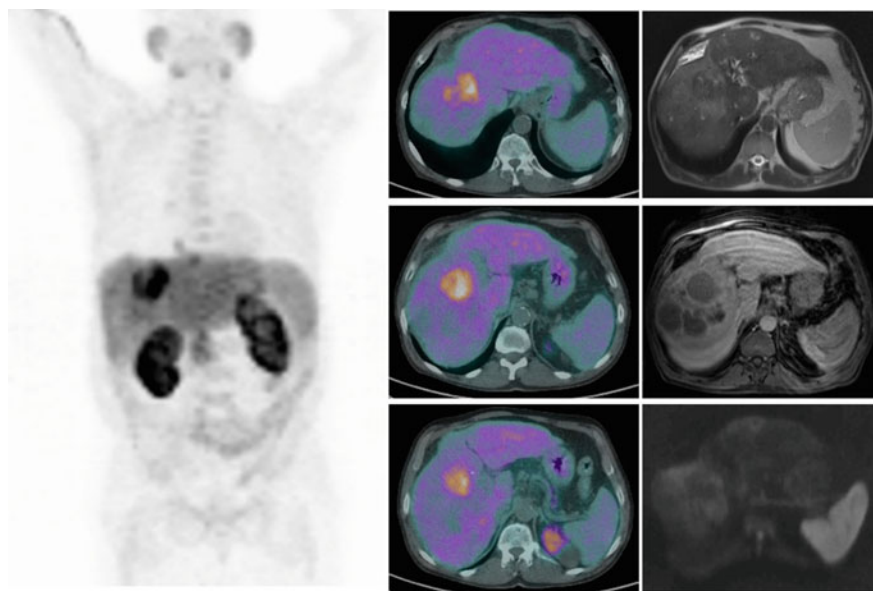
MIP image of 11C-Choline PET/CT of a patient with HCC (left-sided panel of the figure), plus transversal fused images at the level of the liver and corresponding MRI, respectively, in top-down order: T2-weighted haste, T1-weighted vide and Diffusion-weighted views
